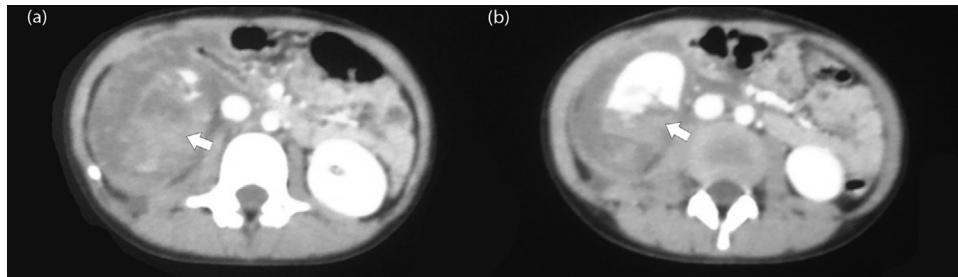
(A, B) Axial view of the contrast-enhanced abdominal CT indicating a grade 5 right renal trauma with active perirenal hemorrhage.
